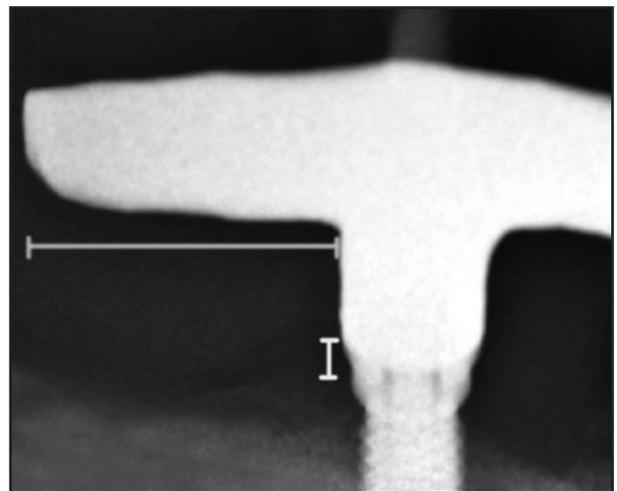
X-ray showing the measurements of bone loss related to cantilever length.
